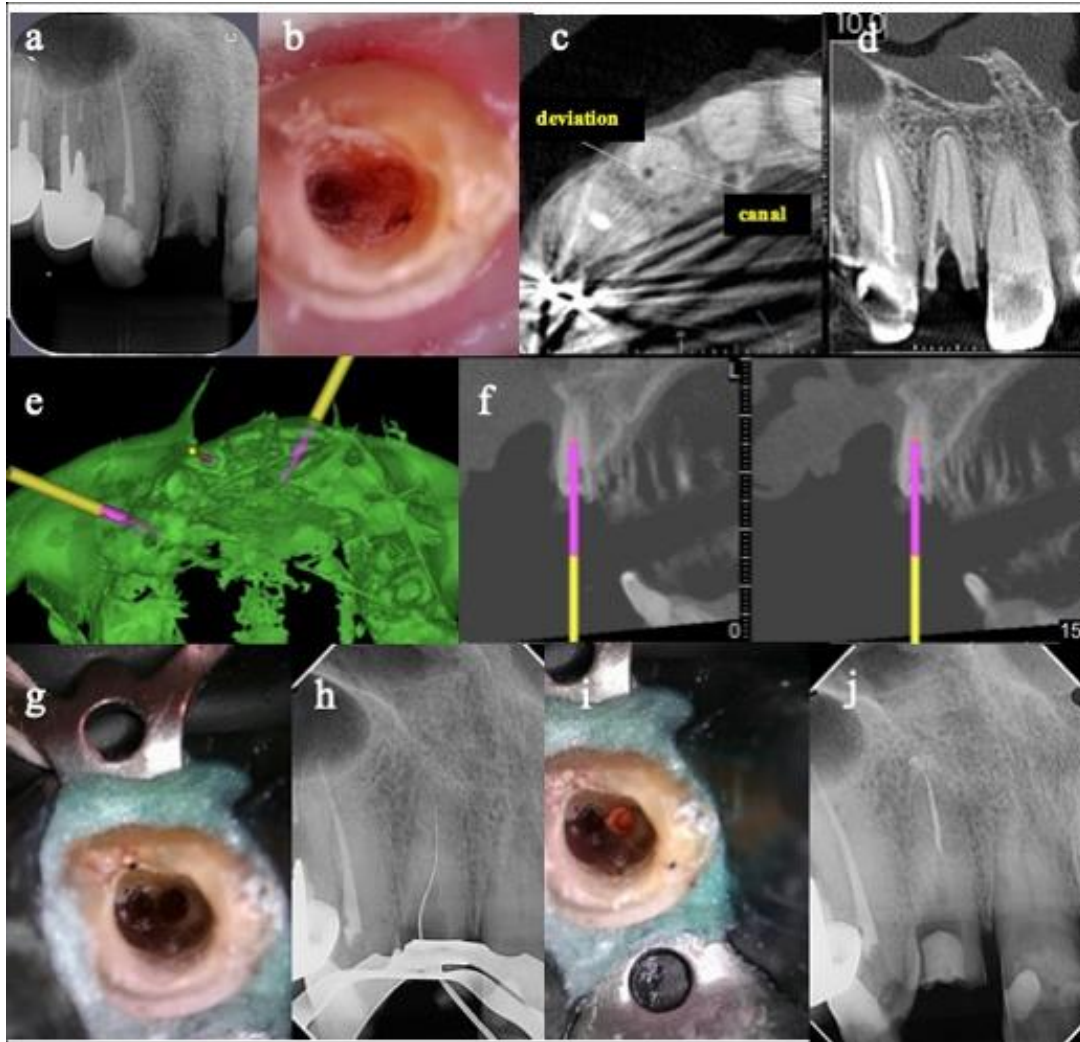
A) Preoperative radiographic image showing partial obliteration of the root canal and an extensive coronary fracture; B) Preoperative clinical view of the pulp chamber; C) CBCT axial image showing partial obliteration of the root canal and a distal deviation; D) CBCT coronal image showing partial obliteration of the root canal and a distal deviation; E) A 3D model of the oral cavity; F) 3D root canal planning; G) Clinical view after the localization of the root canal and cleaning and shaping procedures; H) Working length radiograph; I) Clinical view of the deviation after obturation; J) The final radiograph
